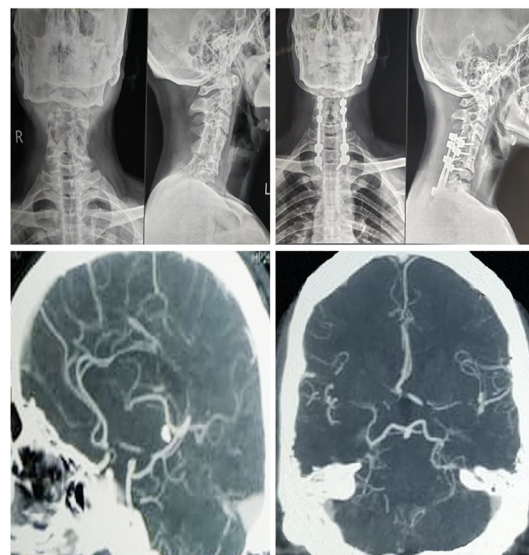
Preoperative and postoperative radiographs of the spine showing the spinal stabilisation for the translational injury and postoperative CT angiogram showing hypoplasia of the A1 segment of the right anterior cerebral artery.
